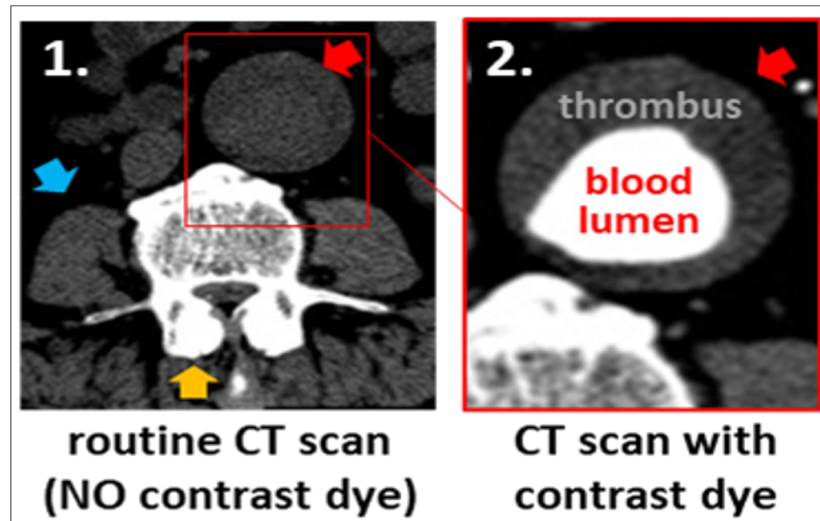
Axial slice from a Computed Tomography (CT) scan with and without the use of an intravenous iodinated contrast agent. IV contrast enhances visualization of the vasculature and allows for diagnosis of vascular pathology¹¹.
